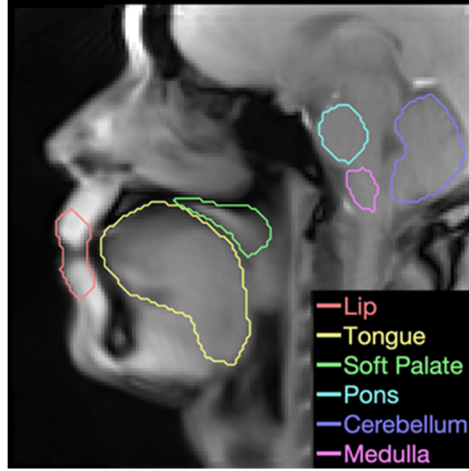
Annotated ROI of lip, tongue, soft palate, palatine tonsil, pons, and cerebellum on a sagittal pharyngeal MRI acquired at 55 fps.
